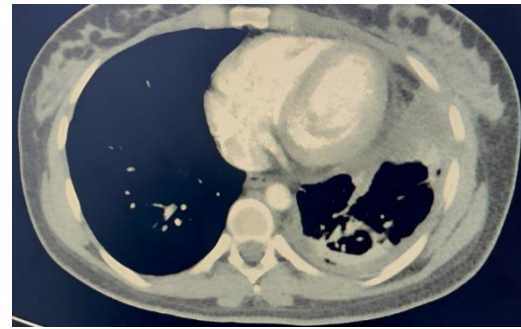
a. CT scan that shows the presence of colonic loops in the left hemithorax, with secondary pulmonary atelectasis and left pleural effusion.
